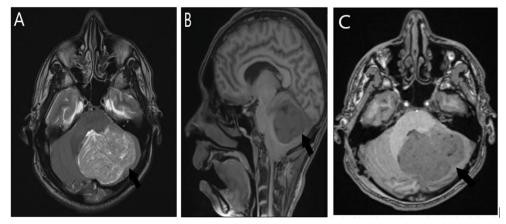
(A) T2-weighted axial MR image. The mass is predominantly hyperintense, with the typical alternate high- and normal-signal-intensity bands. The fourth ventricle and other cerebrospinal fluid spaces are compressed. (B) Sagittal T1-weighted MR image shows the typical striated appearance, with hypo- and isointense bands. The fourth ventricle is compressed and hence is not adequately depicted and the cerebellar tonsil is inferiorly displaced. (C) T1-weighted contrast material-enhanced axial MR image. The mass does not show any appreciable enhancement.
